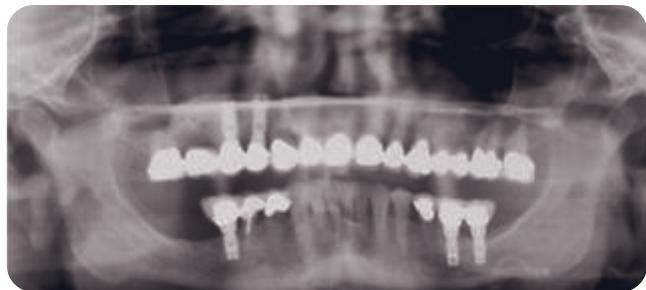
Posttreatment panoramic radiograph. Note sinus graft upper right.
